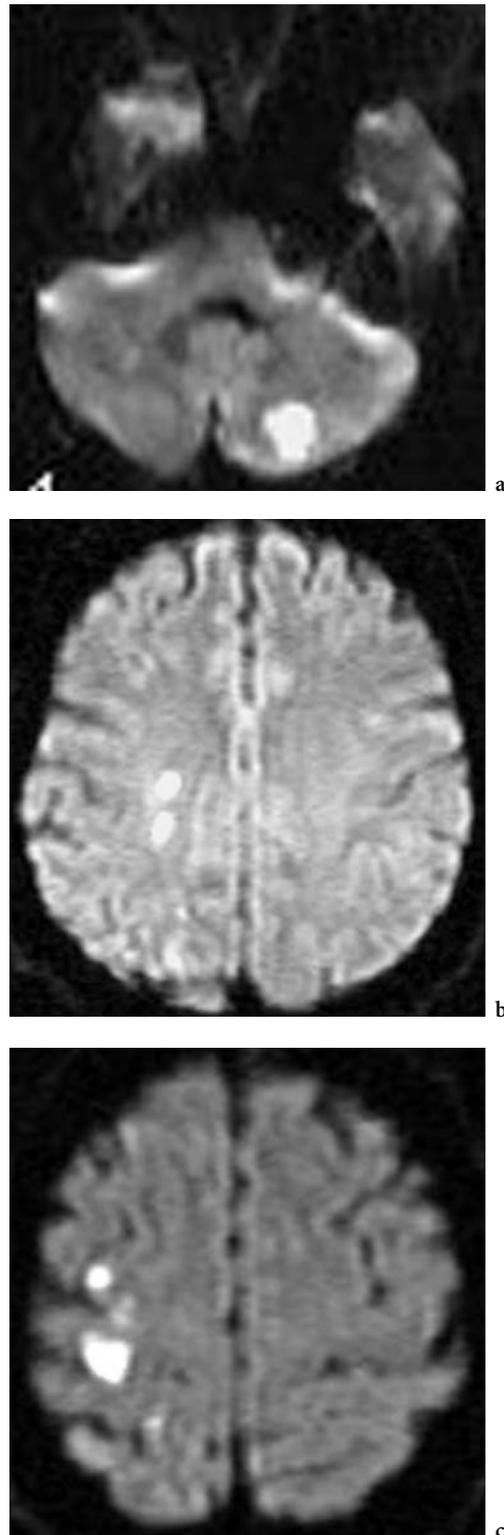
a DWI with silent small infarct of the PICA after embolization of a left vertebral aneurysm. b, c DWI showing small acute cerebral infarctions in the territory of the MCA after embolization of an unruptured right paraophthalmic aneurysm; the patient had no neurological symptoms
